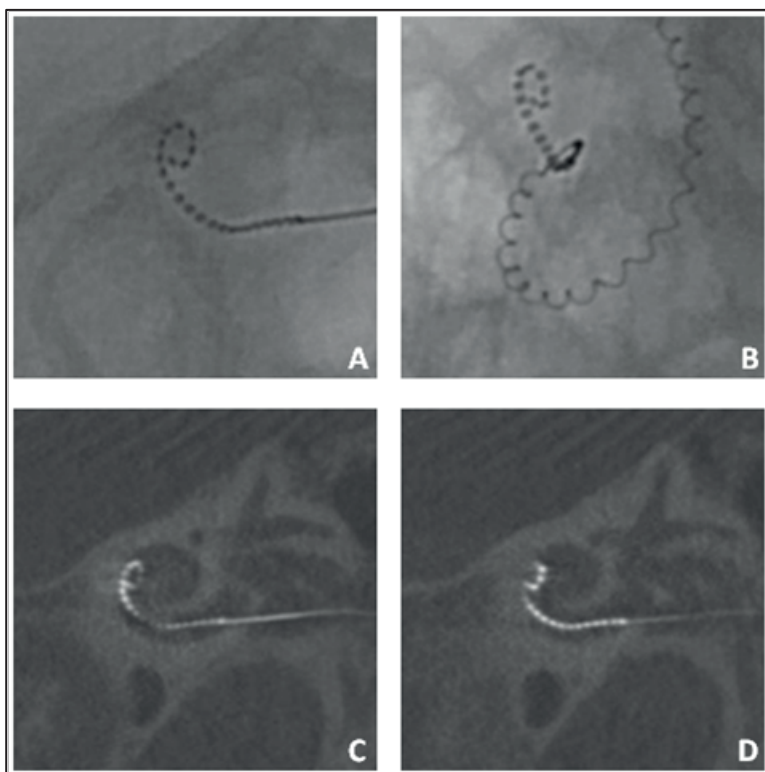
Images of the patient with a tip fold-over (Figures A and B: Fluoroscopy, Figures C and D: CT – scan).
